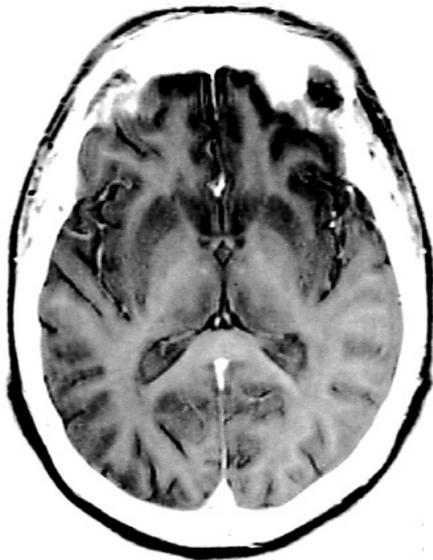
An inverted MRI scan (horizontal view) of the brain through the frontoparietal operculum. Note the curved midline anterior commissure rostral to the columns of the fornix. The splenium of the corpus callosum and the posterior horn of the lateral ventricle are also visible
